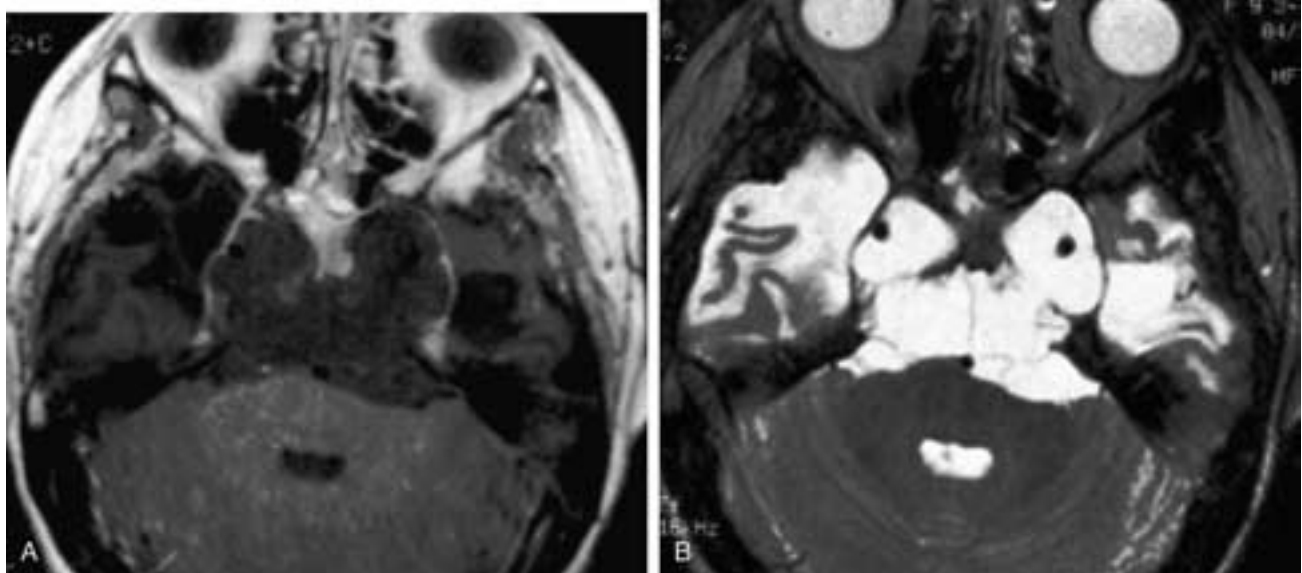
Chordoma after treatment. A, The expansile lesion of the basicranium shows very little enhancement. Note the changes in the contiguous temporal tips from radiation therapy. B, Axial T2-weighted image shows the typical high signal within the lesion and abnormal signal in the temporal lobes.
